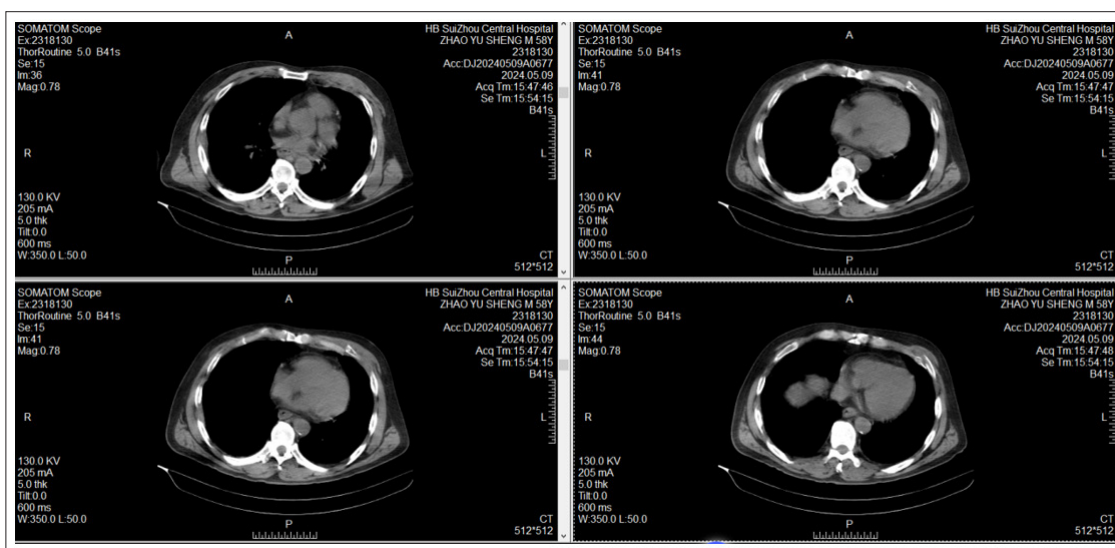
Mediastinum CT examination on admission on May 9: Calcification in descending aorta, suspected endometrium shedding
